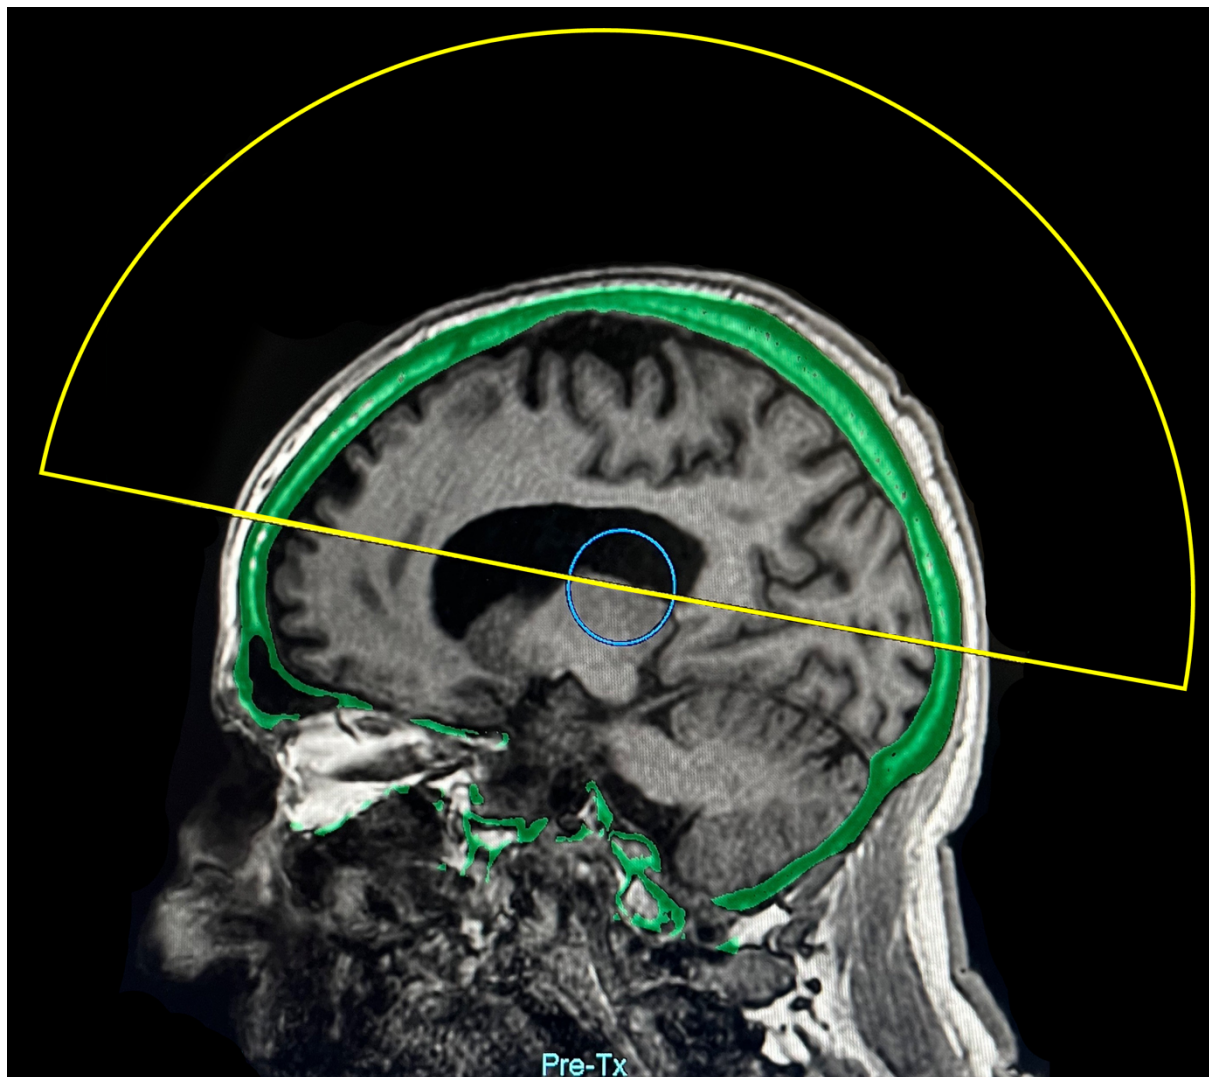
Sagittal view of planning T1-WI acquired with MRI body coil. Skull segmentation from co-registered planning CT shown in green, US transducer shown in yellow, and transducer focal point indicated by blue circle.
